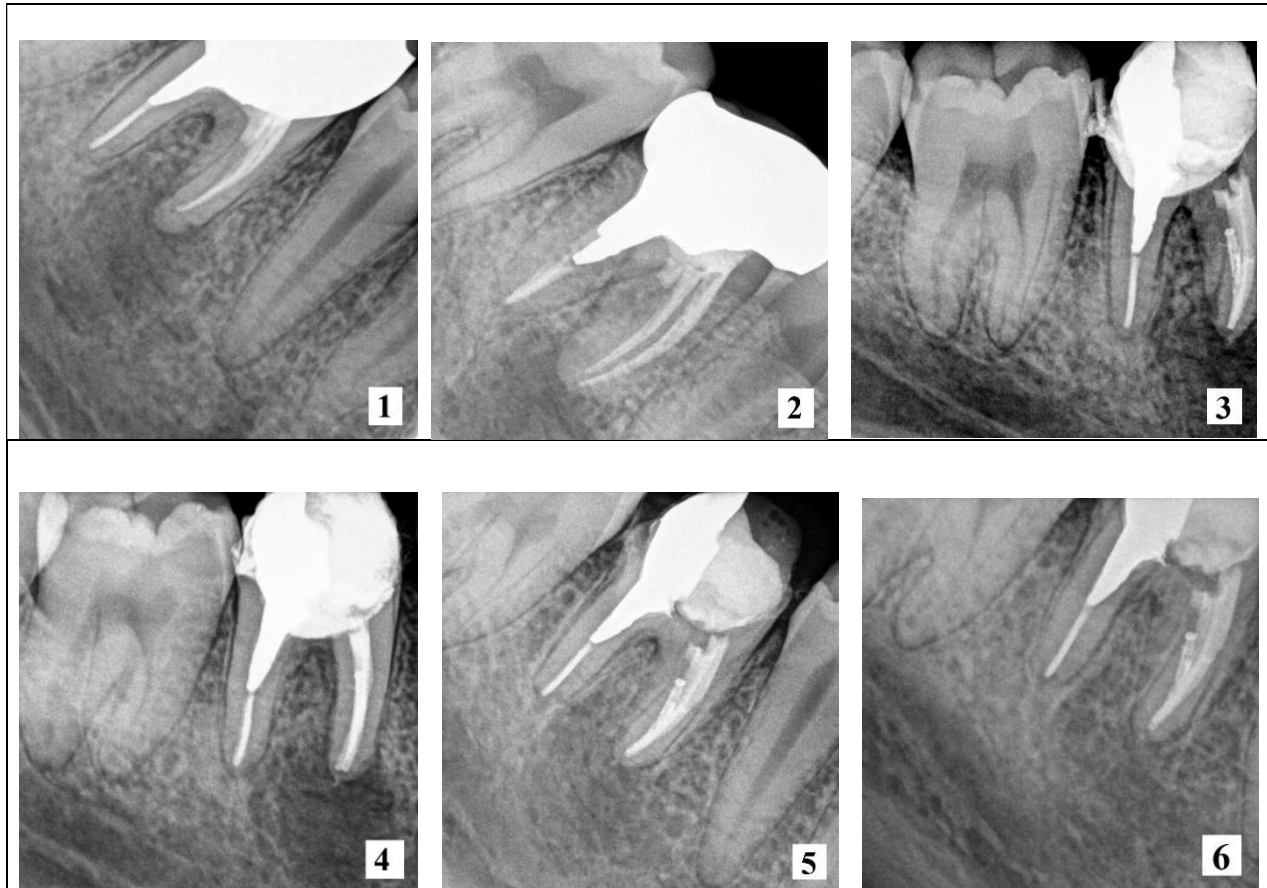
Preoperative periapical radiographs the right side of the lower jaw first molar. Fig. 3, 4. Postoperative radiograph the right side of the lower jaw first molar. Fig. 5. Follow-up after 6 month. Fig. 6. Follow-up after 14 months.
